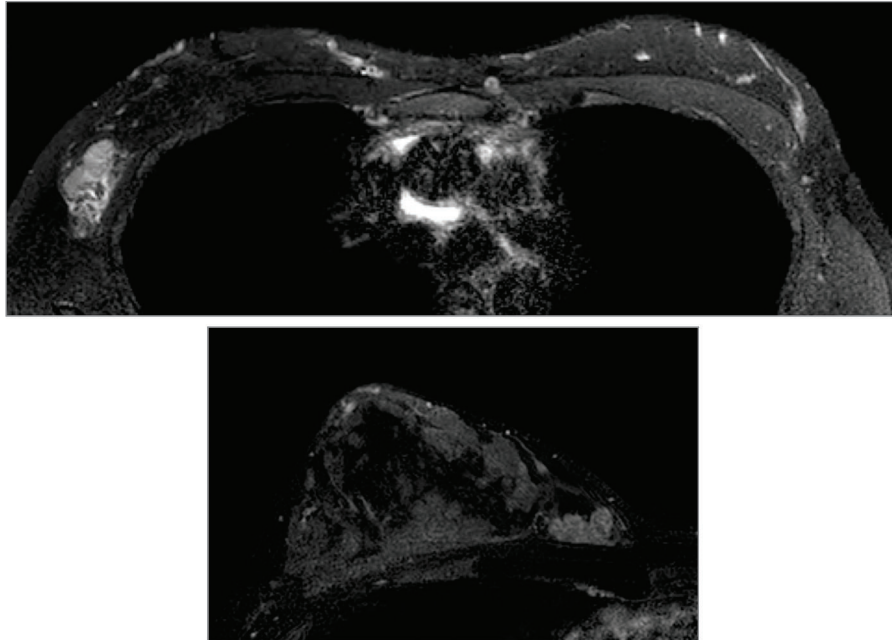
Top, Axial T2-weighted magnetic resonance imaging (MRI) at the level of the axilla. Bottom, Axial postcontrast T1 fat-saturated MRI of the right breast.
